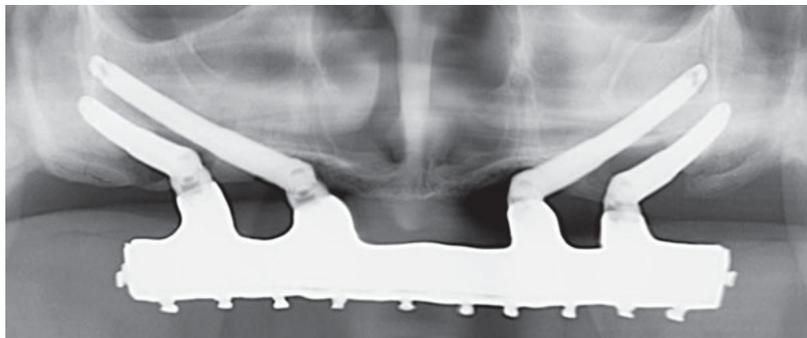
Panoramic radiograph at 1-year after loading of one of the patients with a severely atrophic maxilla randomly allocated to receive four immediately loaded zygomatic implants (Dr Roberto Pistilli, Rome).
